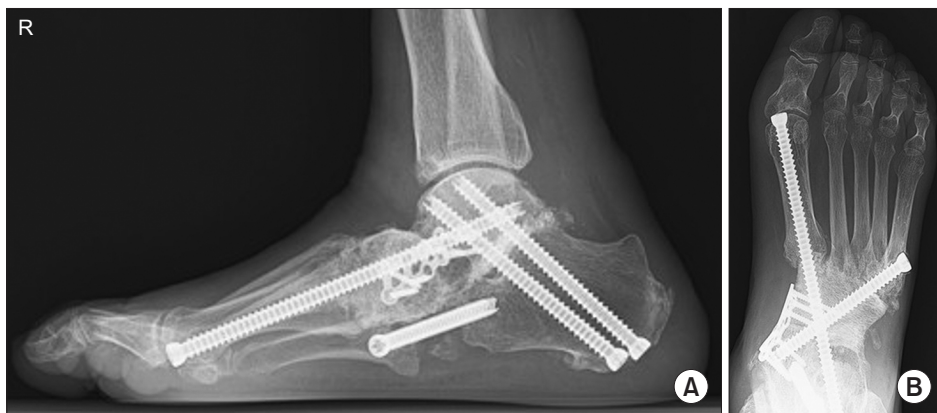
Plain foot radiographs at 13 months postoperatively.
